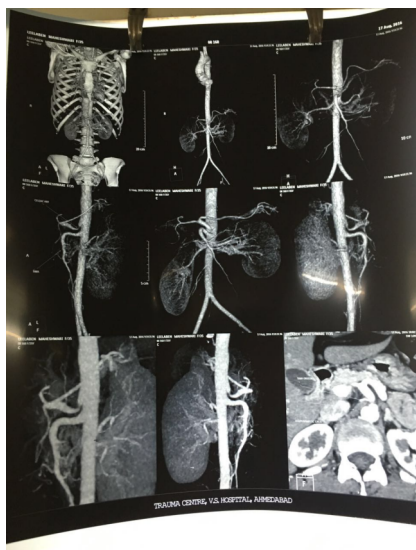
CT Angiogram MALS
